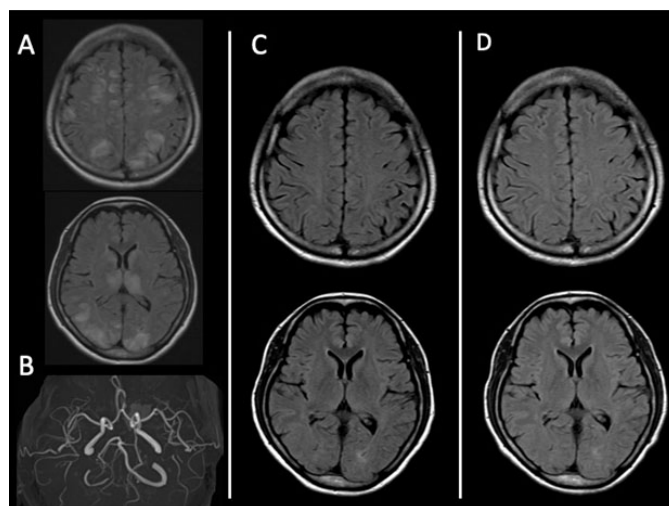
Head MRI findings (Case 1) (A) FLAIR at onset. (B) MRA at onset. There was no occlusion or stenosis of the vessels, including bilateral PCA. (C) FLAIR taken at nine days after onset. (D) FLAIR taken five months after onset. MRI, magnetic resonance imaging; MRA, magnetic resonance angiography; FLAIR, fluid-attenuated inversion recovery.
